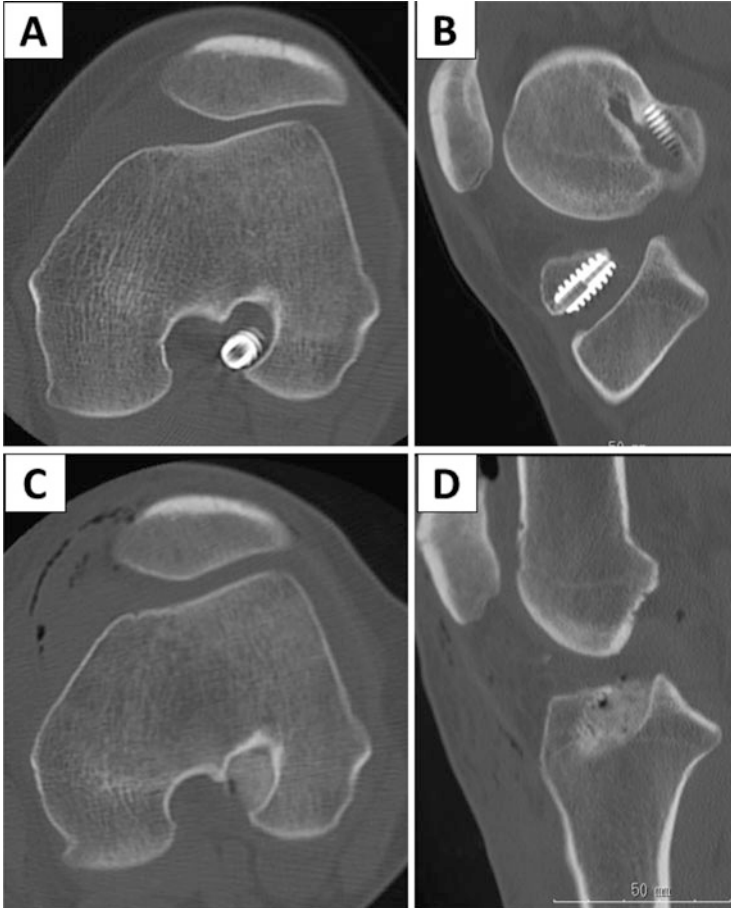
Two-staged surgery case with bone grafting of the tunnels. Twenty-seven years old female. Preoperative CT images; (a) axial view and (b) sagittal view. Postoperative CT images (after autologous bone grafting); (c) axial view and (d) sagittal view
